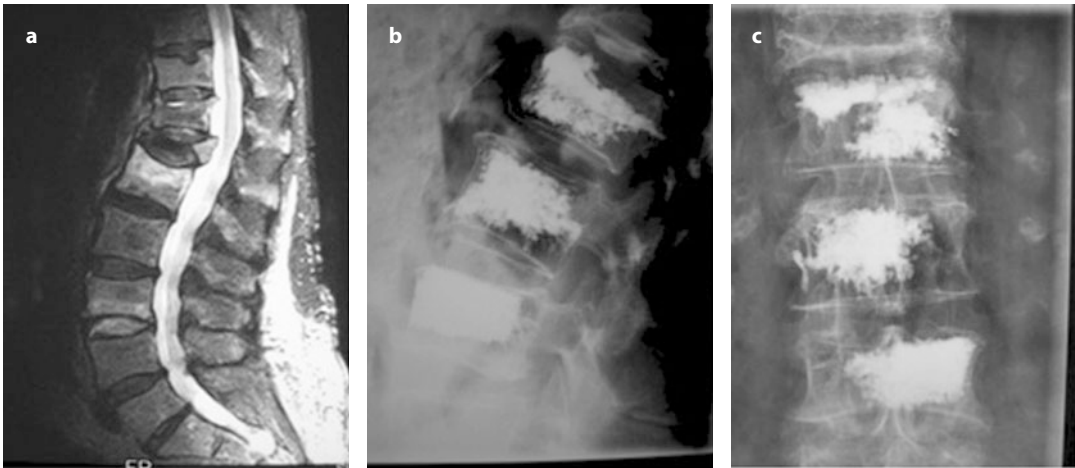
75-year-old female with severe osteoporosis. Sagittal T2-weighted MRI shows complete collapse of the T12 level with hyperintense signals at L1 and L3 levels (a). Left lateral and anteroposterior views under fluoroscopic control after VP at L1–L3 levels (b and c)
